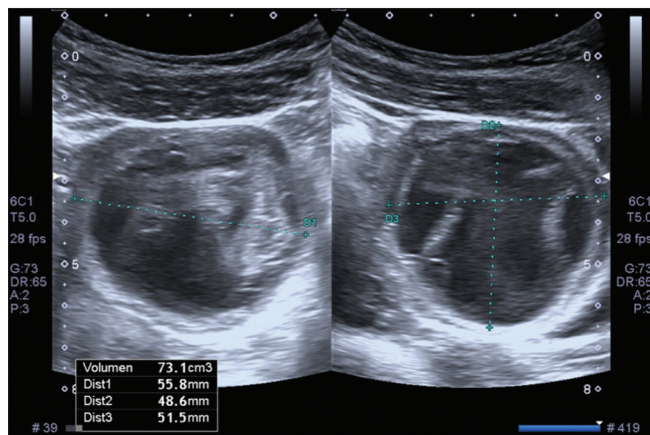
Ultrasound appearance of the torted ovary. In the images, we can observe a heterogenic cyst of 56 mm × 49 mm × 52 mm with septums
